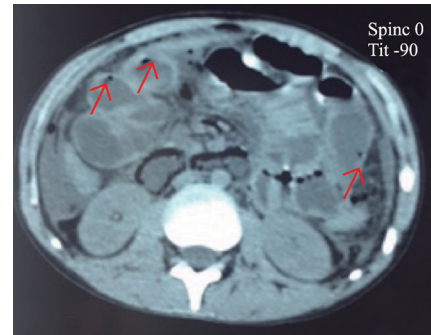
CT showed intraperitoneal effusion and pneumoperitoneum and parietal pneumatosis.
